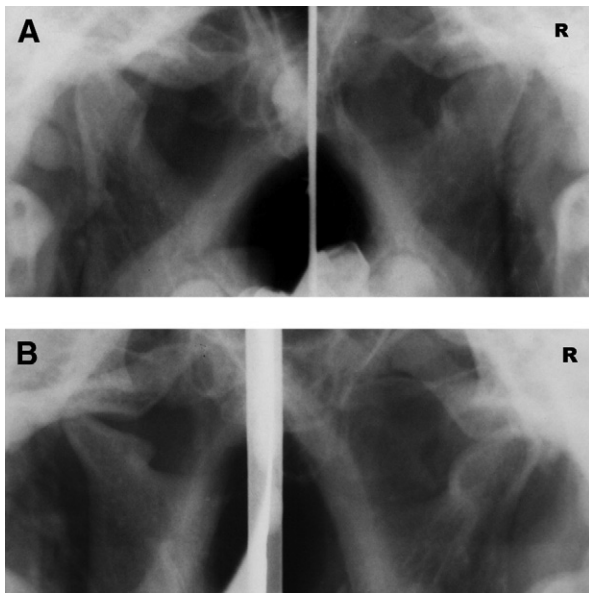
Samples of a representative 14-year-old woman. A, Transpharyngeal radiogram showed flattening and sclerosis of the condyle. B, The radiographic changes of condyles became more severe, especially on the left side, in the same patient 5 years later.
